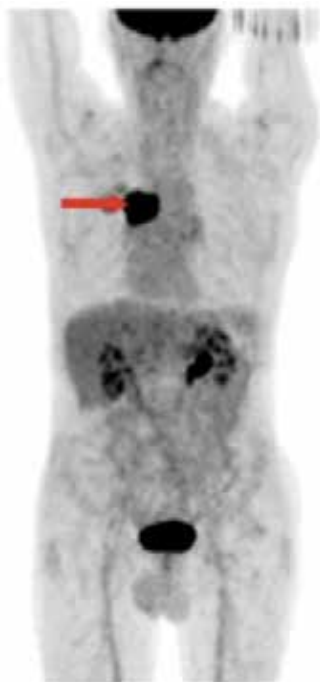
A FDG +ve right hilar squamous cell carcinoma.
